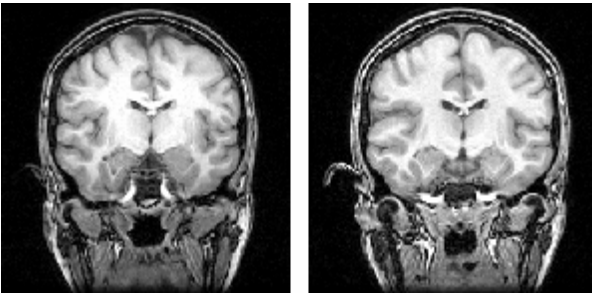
Structural MR images. Left: Original image, Right: Image after intensity non-uniformity correction.
